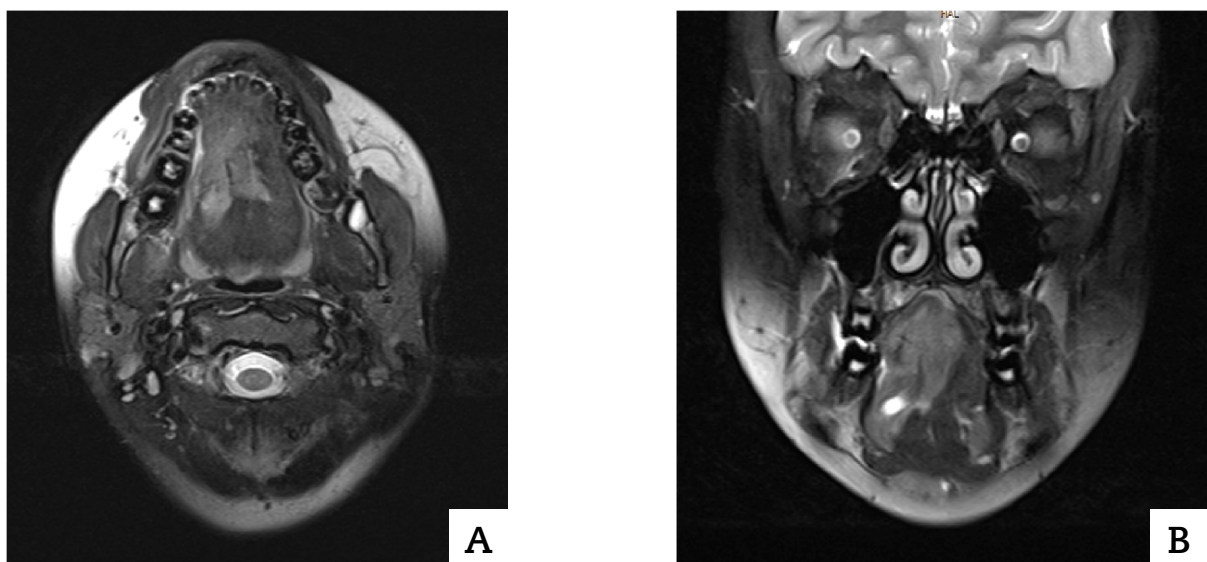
MRI done in our hospital. Axial (a) and coronal (b) cuts of the primary lesion.
